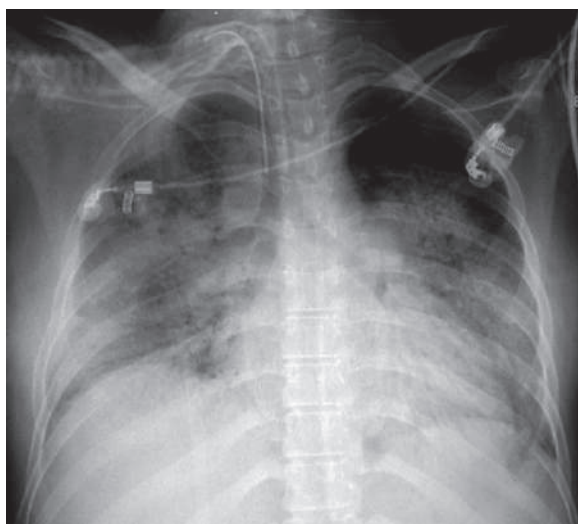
Posteroanterior plain chest radiograph of a patient with cytomegalovirus (CMV) pneumonia after heart transplant shows mixed patchy lung infiltration with micronodular interstitial lung pattern
